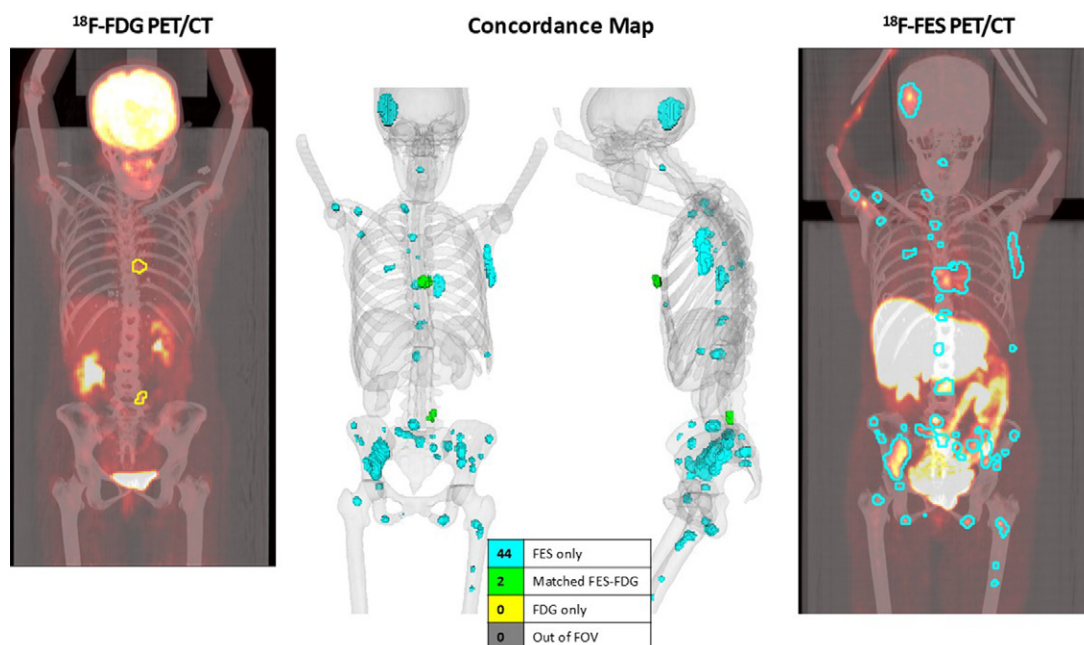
In one selected participant with invasive lobular carcinoma, the automated concordance tool (center) highlights two lesions (green), which were found in both the (left) fluorine 18 (^{18}F)-fluorodeoxyglucose (FDG) PET/CT and (right) ^{18}F -fluoroestradiol (FES) PET/CT images, whereas 44 lesions (light blue) were identified in only the ^{18}F -FES PET/CT image and none were found in only the ^{18}F -FDG PET/CT image.
